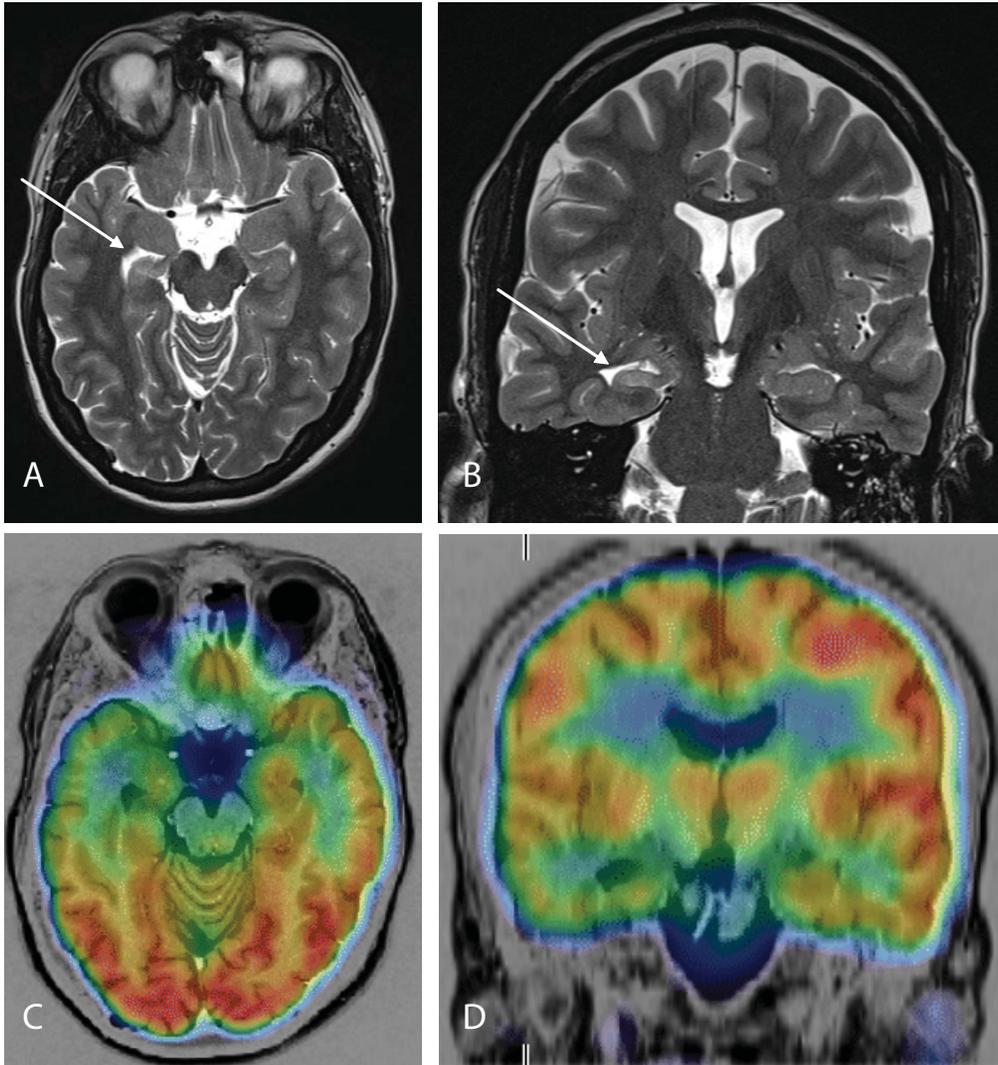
Typical imaging findings in hippocampal sclerosis. A 41-year-old woman with a 23-year history of TLE. Three Tesla MRI reveals a right-sided hippocampal sclerosis (white arrow) and the seizure onset is from the right temporal lobe according to the ictal EEG recording (Axial and coronal T2 images, A-B). FDG-PET image is fused with MR-imaging and it shows wide hypometabolism in right temporomesial and temporal neocortical areas (C-D).
